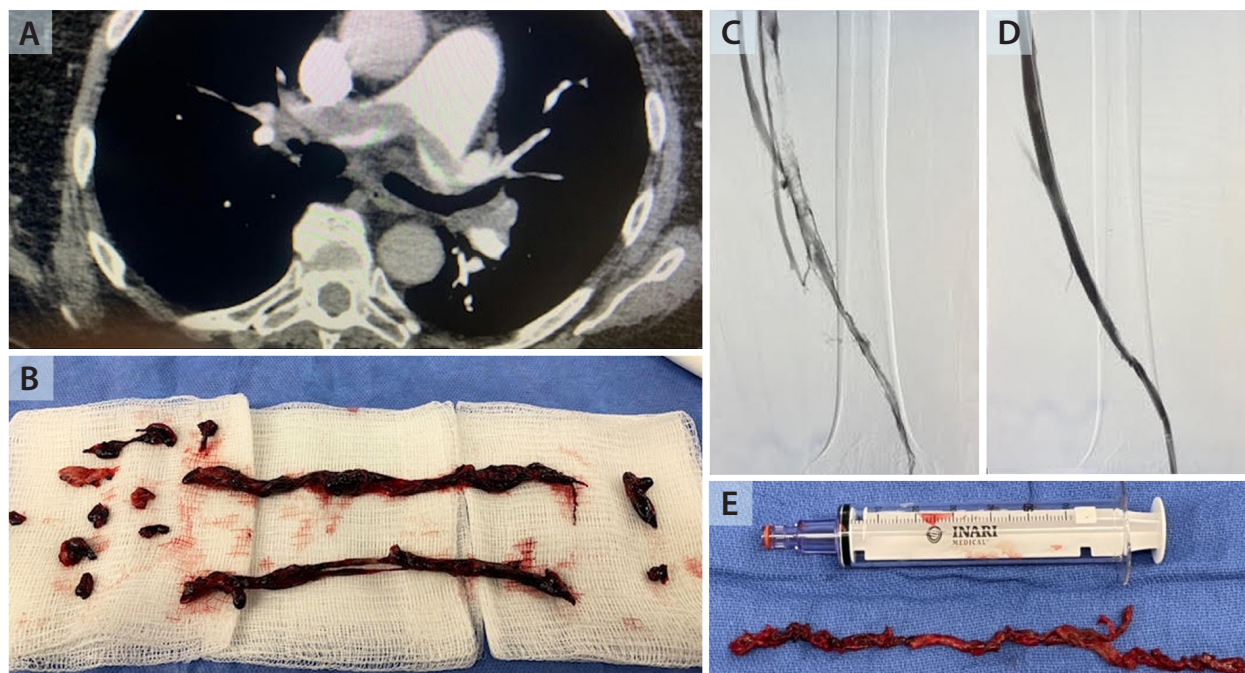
CT scan revealed bilateral and saddle PE (A). Thrombectomy performed with the FlowTriever System extracted significant thrombus (B). In a separate procedure to treat the DVT the next day, venography was performed on the right lower extremity, revealing a dilated right femoral vein with significant thrombus burden throughout the femoral, superficial, and popliteal segments. The right popliteal vein had diffuse thrombus and fibrotic stenosis (C). Final venography demonstrated return of flow and no significant thrombus remaining (D). Thrombus was extracted from the right lower extremity using the ClotTriever System (E).
